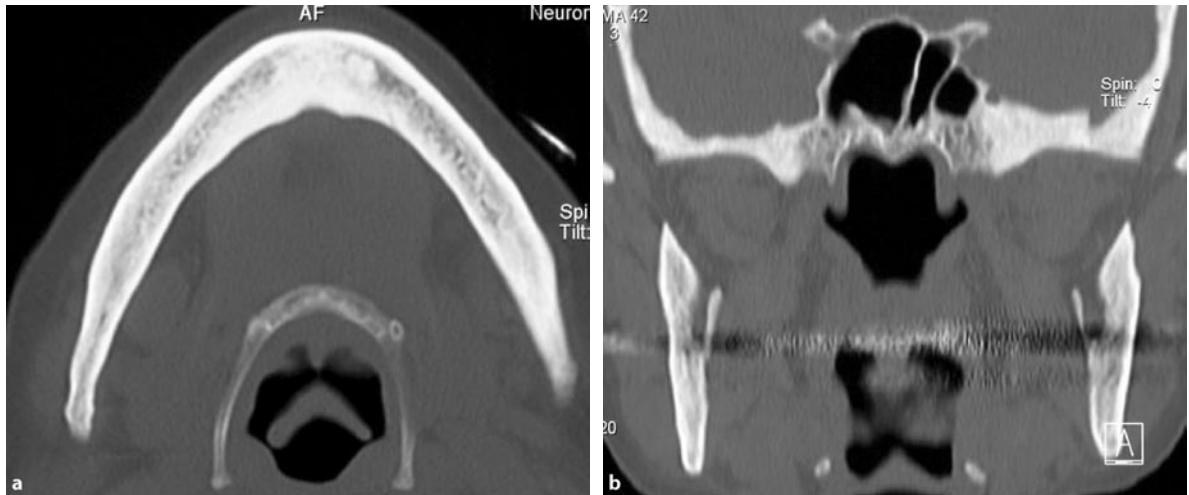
Osteomyelosclerosis: a 51-year-old woman with a known systemic disease leading to pancytopenia. Evaluation of the mid- and lower face because of trauma. Axial and coronal high-resolution bone-window CT images (a,b) reveal uniform increased density of cancellous
